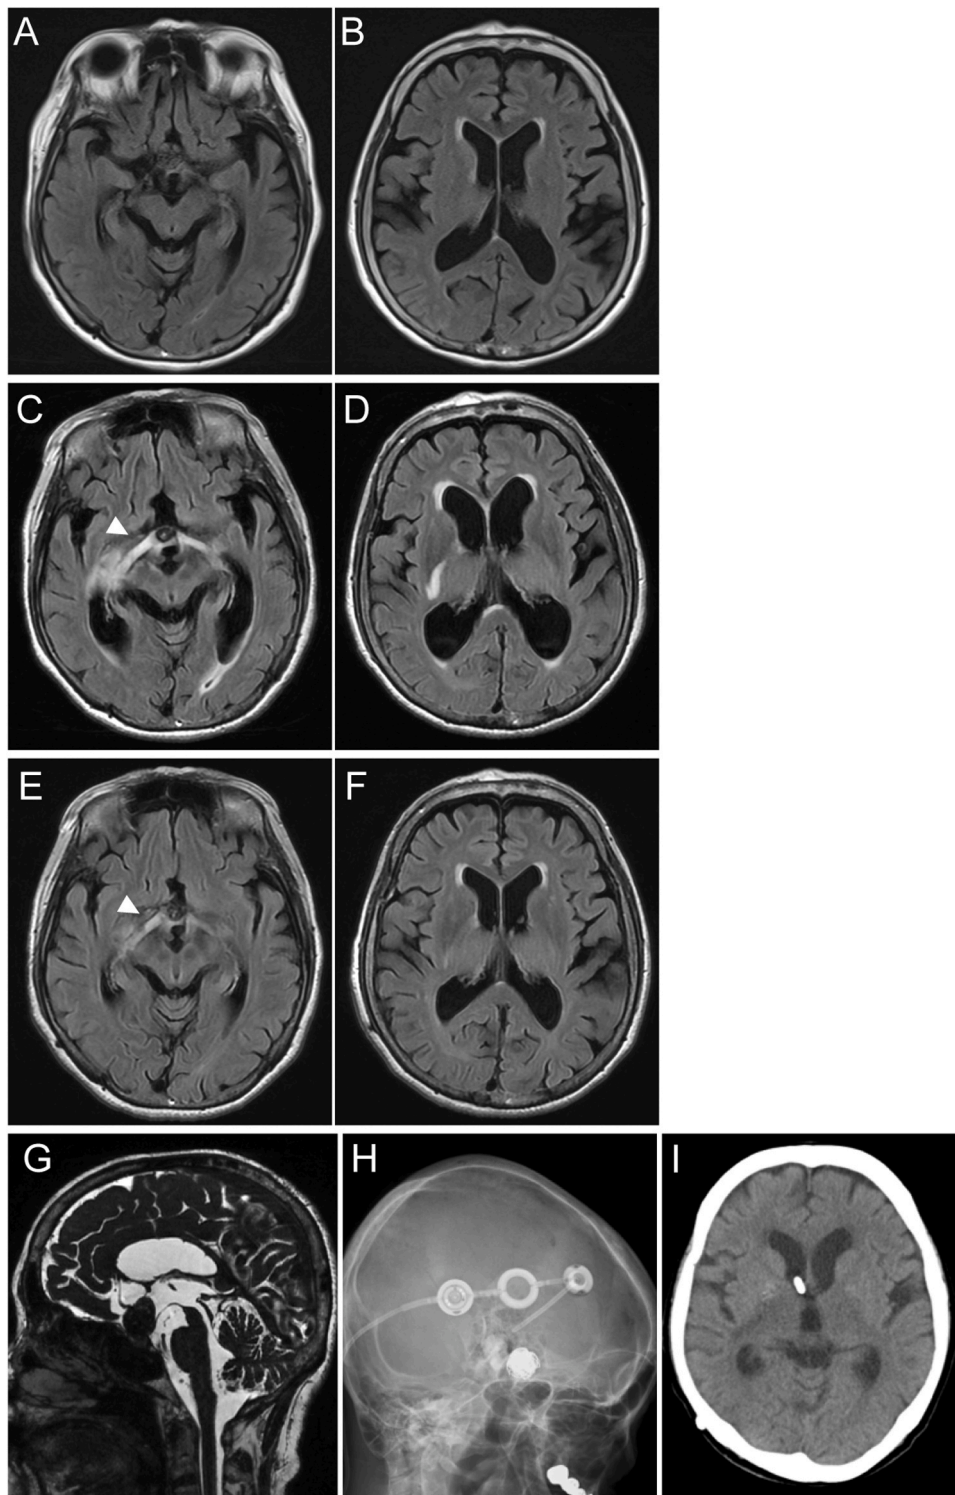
Time course for edema change around ventricles. A-F. MRI FLAIR images just after flow diverter placement and coil embolization (A, B), just before ventriculoperitoneal shunt (C, D), and 6 months after endovascular surgery or 3 months after shunt placement (E, F). Arrowheads indicate the edema along the optic tract. G. A cisternographic image before shunt placement. H, I. An X-ray image (H) and a CT scan image (I) after shunt placement.
